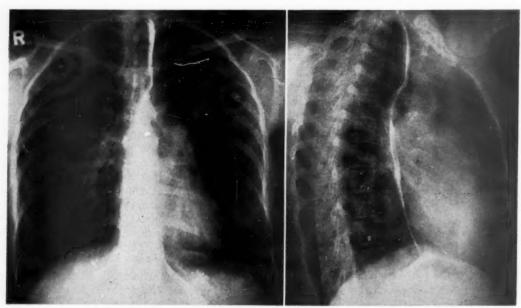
Posteroanterior and lateral roentgenograms of patient J. H.
